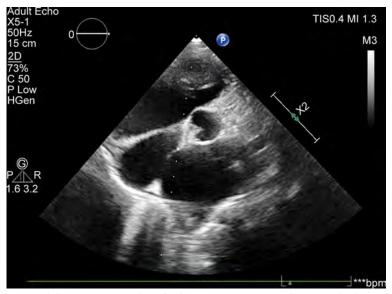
Parasternal short axis view in diastole showing unicommissural unicuspid valve
